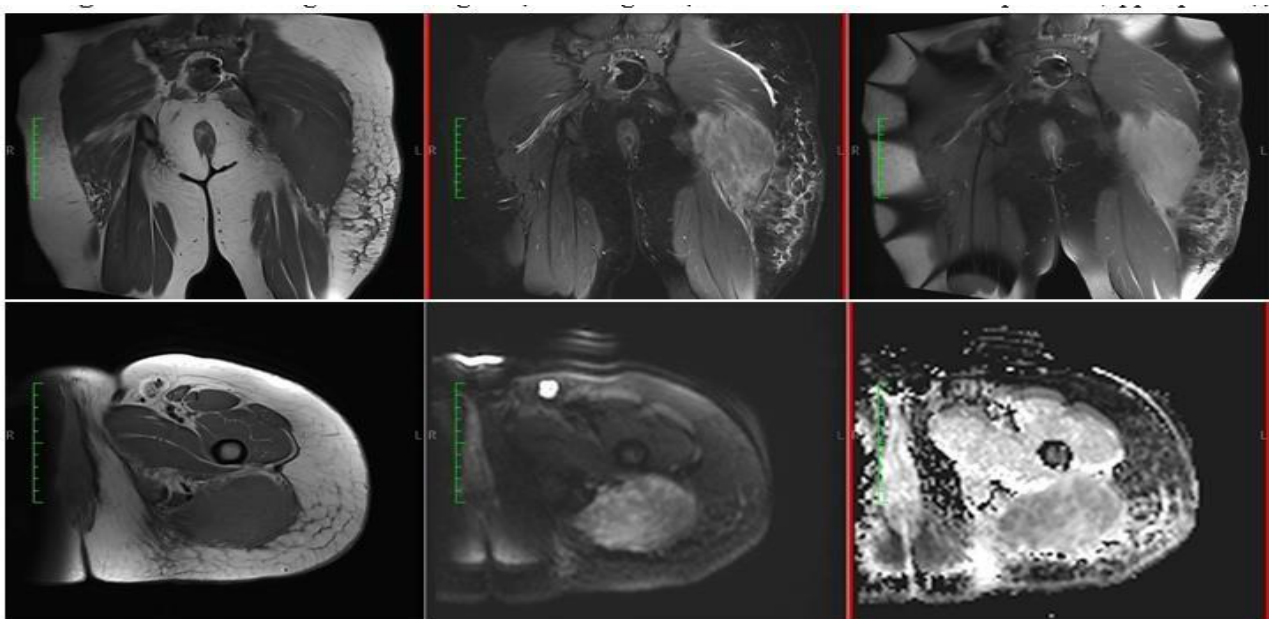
MRI findings on T1-weighted, T2-weighted, and contrast-enhanced sequences (upper panels), and MRI findings
